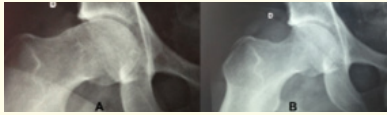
Patient with cam FAI in right hip. (A) Preoperative radiograph of right hip in Dunn view at 45° with an alpha angle of 94° and (B) postoperative radiograph in the same view after femoral osteoplasty via arthroscopy, using the extracapsular technique at an alpha angle of 50°. Source: Patient treated in this study.
